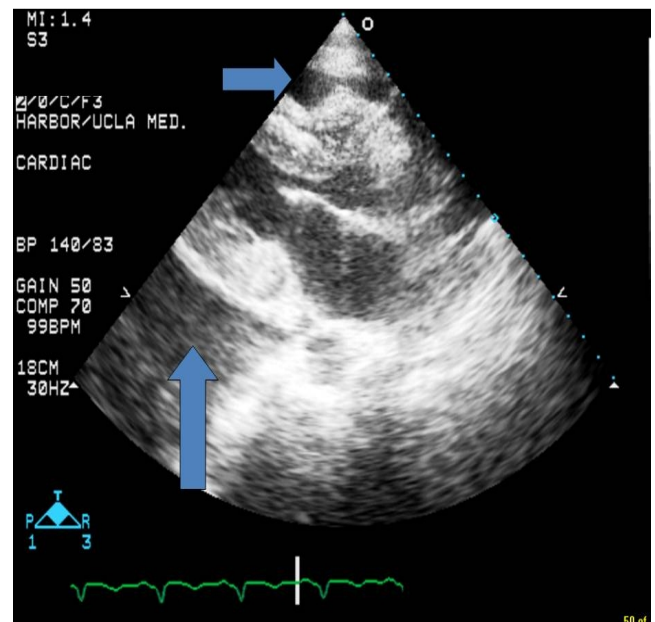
2-Dimensional Transthoracic Echocardiography, long-axis parasternal view demonstrating a large pericardial effusion (up arrow) and evidence of right ventricular diastolic collapse (right arrow).
